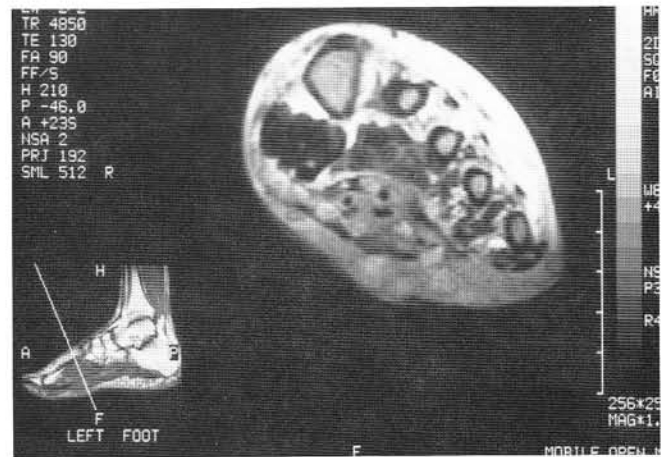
Frontal plane MRI scan demonstrates a multi-chambered cluster of increased soft tissue edema without a well-defined abscess.
